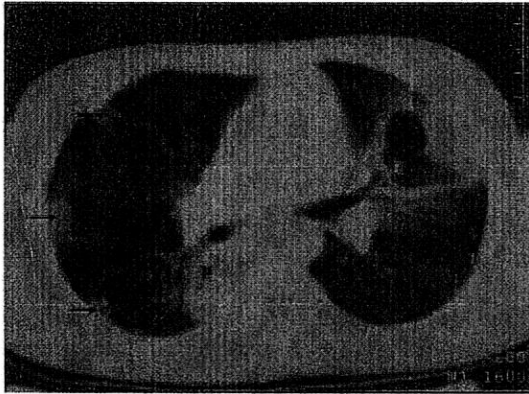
Multiple focal consolidations in CT scan of chest
